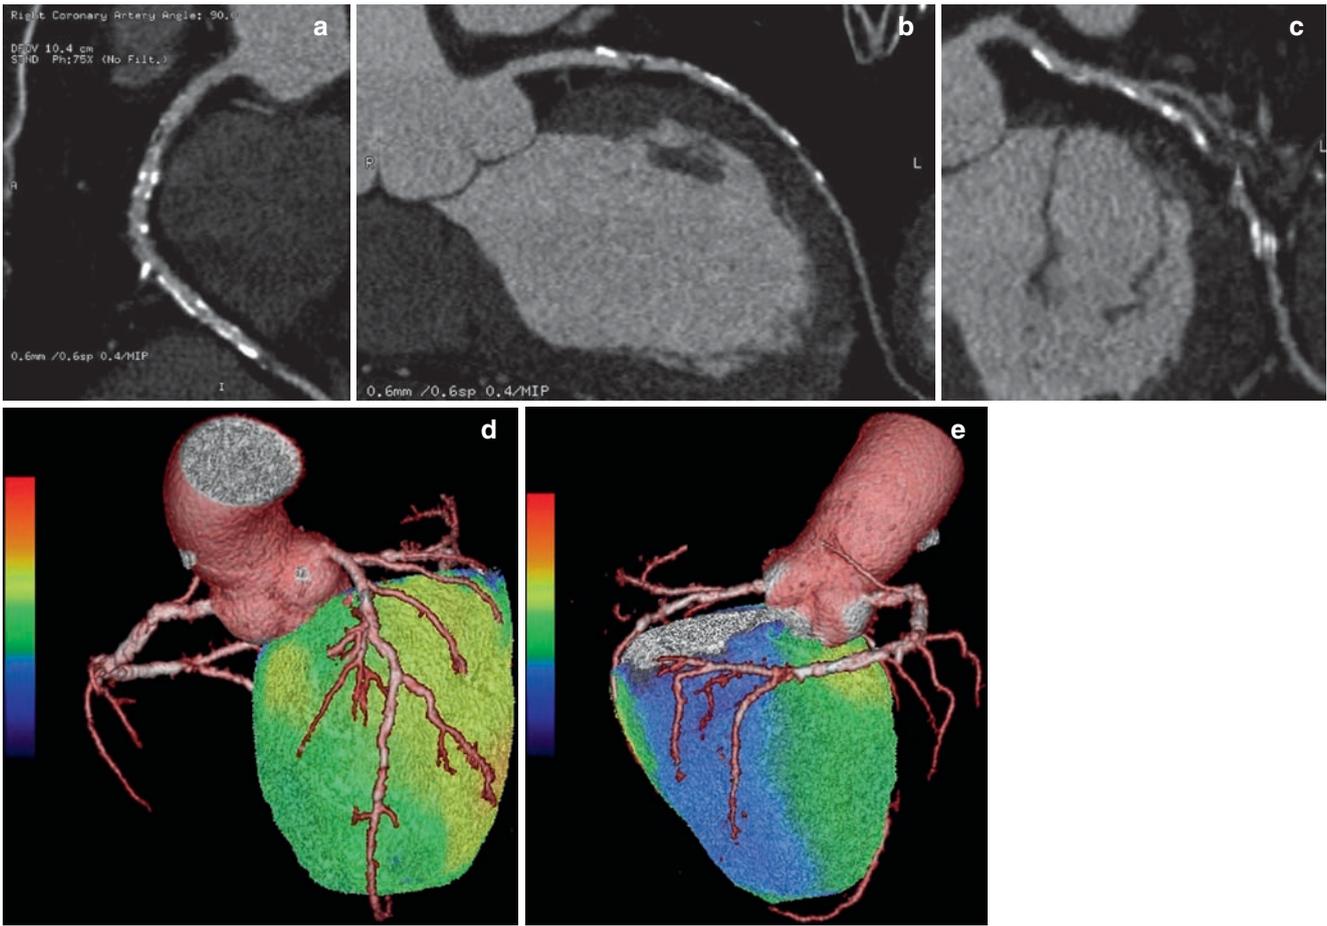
CT coronary angiography images (curved multi-planar reconstructions) of a male patient with effort angina. The images of RCA (a), LAD (b) and LCX (c) show several calcified and non-calcified plaques, which suggest significant multi-vessel disease. Three-dimensional cardiac hybrid PET-CT images of anterior (d) and right
